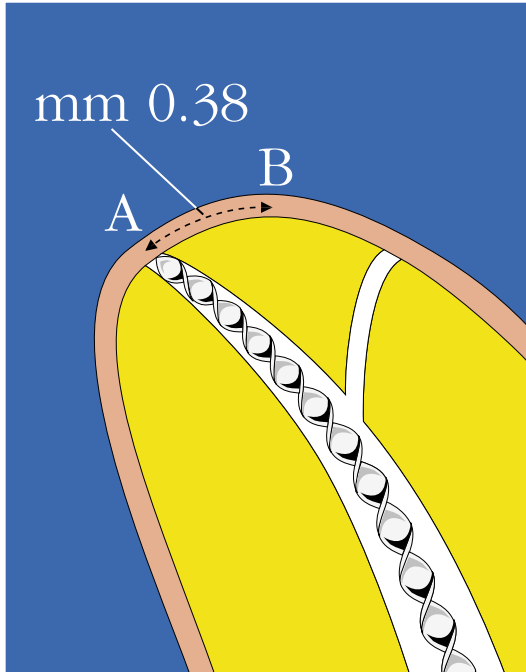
The mean distance between the apical foramen and the anatomic apex (always radiographically visible) is 0.38 mm in Dummer's study. A: apical foramen; B: Anatomic apex; A-B: foramen-anatomic apex distance measured on the external surface of the root.
